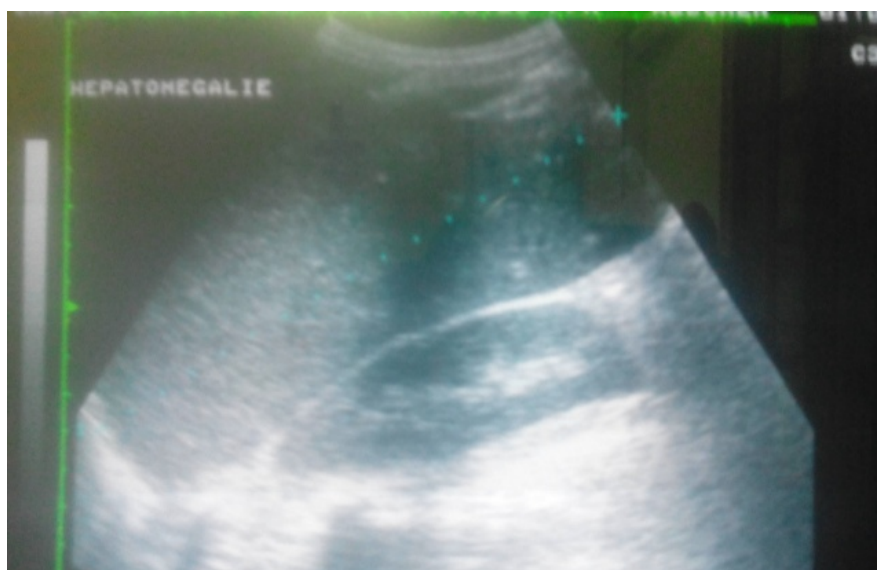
Ultrasound showing Hepatomegaly in our HCV+ patient.
